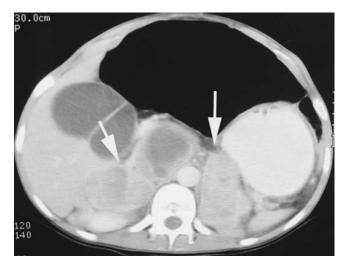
A 26-year-old woman had severe constipation and developed multisystem failure. She was found to have a thyroid nodule and cervical lymphadenopathy. Abdominal computed tomographic scan showed bilateral adrenal tumors (*arrows*). Biochemical workup was consistent with pheochromocytoma, and the patient underwent open bilateral adrenal resection for pheochromocytomas followed by thyroidectomy for medullary thyroid cancer. Genetic study confirmed the clinical diagnosis of multiple endocrine neoplasia type IIB. Courtesy of Quan-Yang Duh, MD.
